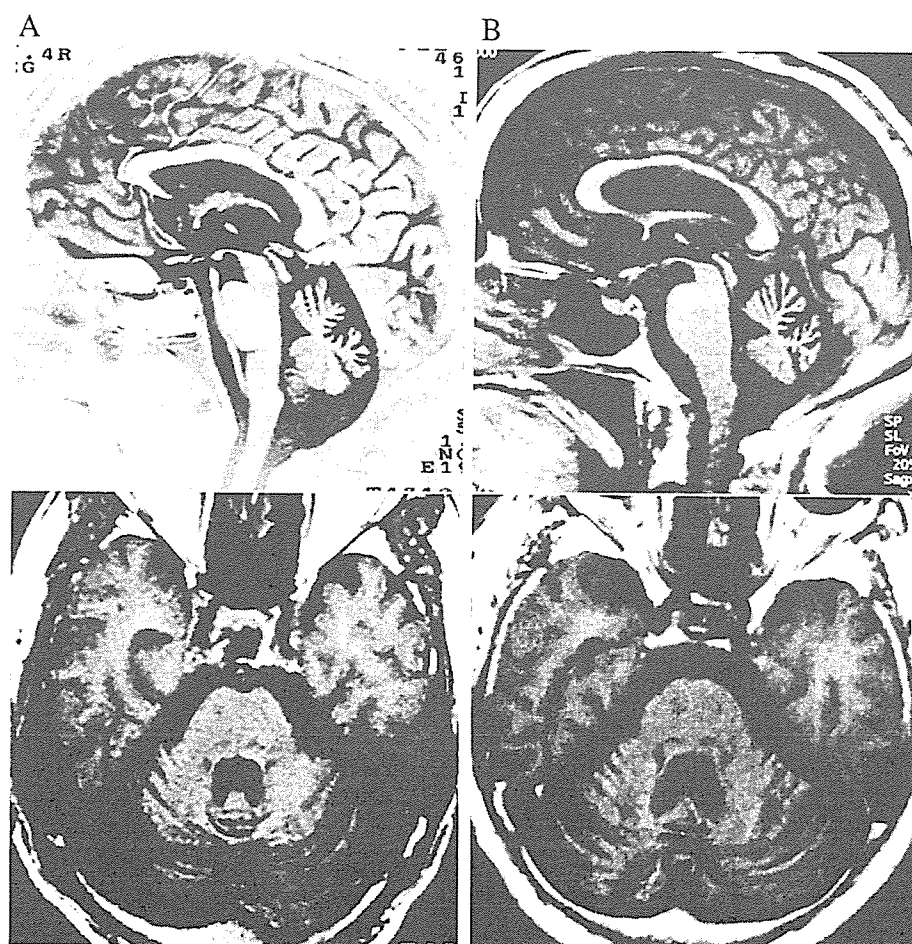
(A) Brain MRI in a homozygous patient (disease duration, 20 years). Top: Reversed T2-weighted, sagittal slice. Bottom: T1-weighted, axial slice. (B) Brain MRI in a heterozygous patient (disease duration, 22 years). Top: T1-weighted, sagittal slice. Bottom: T1-weighted, axial slice. Both patients showed cerebellar atrophy of the same degree.
